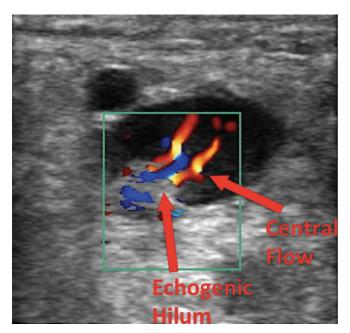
Reactive lymph node with central flow. On color Doppler, there is afferent and efferent flow detected in the hilum of the node.
